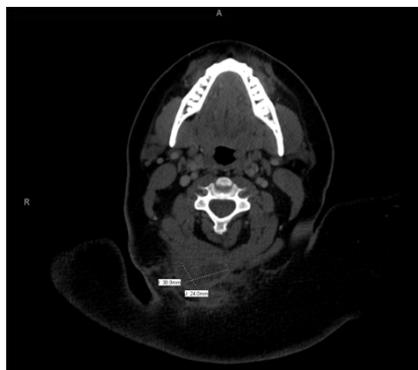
CT Scan Image of a Cervical Soft Tissue Infection with contrast demonstrating a 3.9 x 2.4 cm posterior neck deep space abscess.
